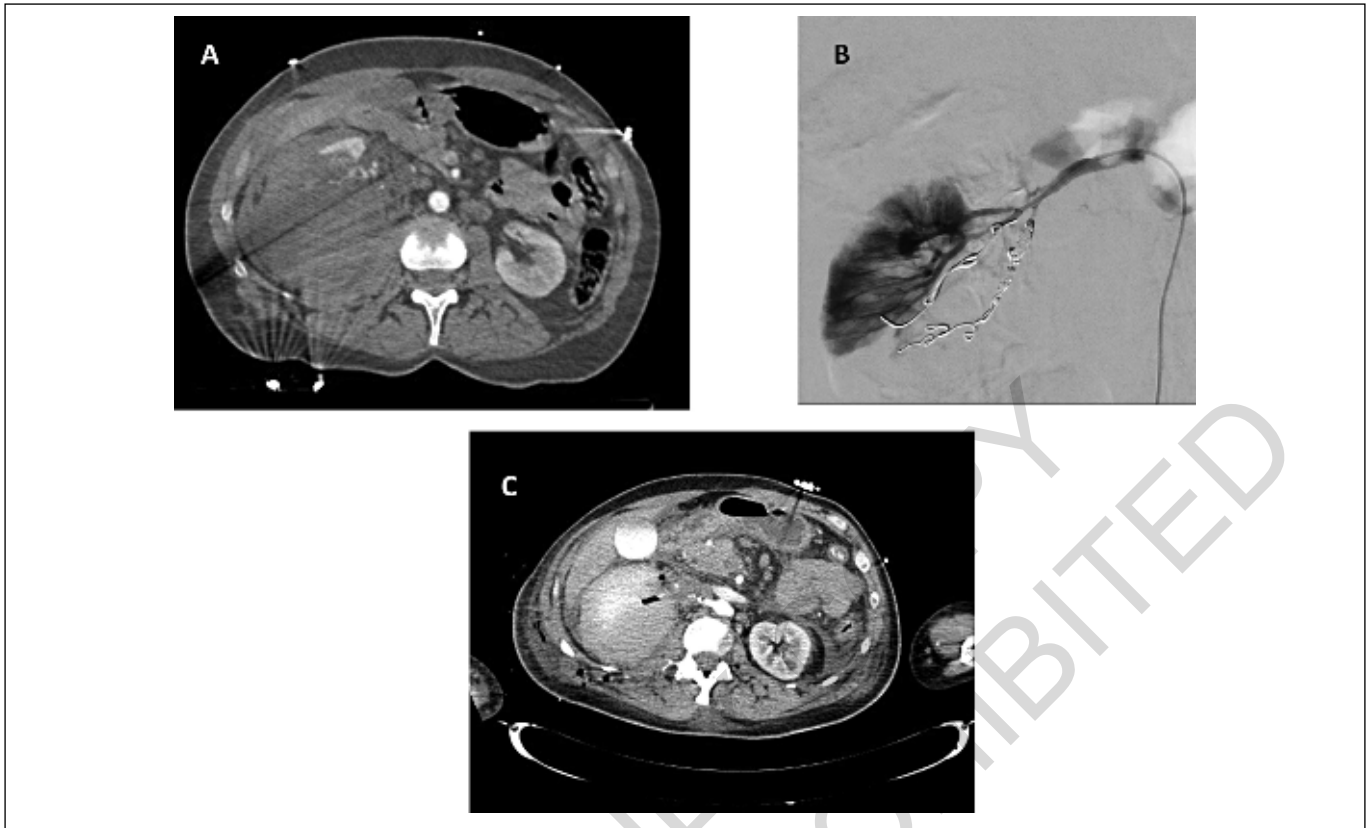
A) CT scan showing active bleeding from the renal artery with perirenal hematoma. B) Control angiography after embolization of the renal artery. Half of the kidney is perfused by a polar renal artery. C) 7th day postoperative control CT scan showing a right perirenal abscess with air and perinephric fluid accumulation.
